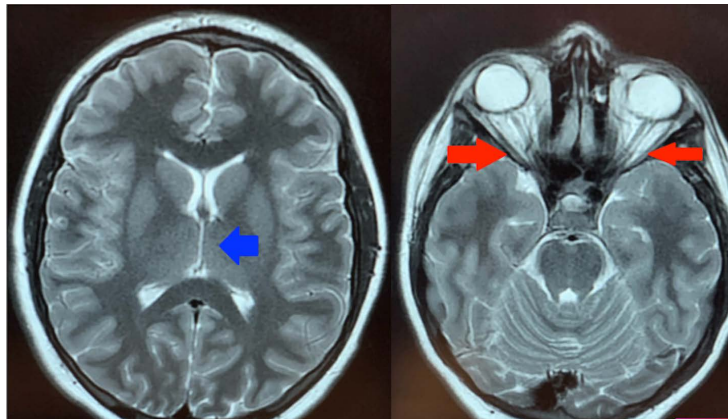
MRI found distention of optic nerve sheaths (Right figure; red arrow) with flattening of posterior globes and pituitary gland. The blue arrow on the left figure indicates slit like ventricles of IIH.
